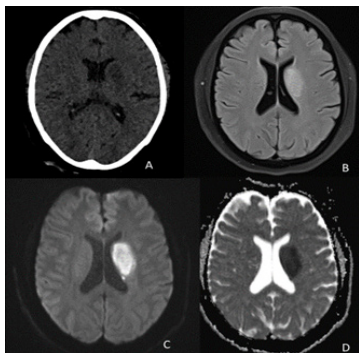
MCA territory infarct. Axial NCCT head (a) shows hypodensity in the left basal ganglia. The corresponding axial T2 (b) shows that the area is hyperintense and showing diffusion restriction on DWI (c) and ADC (d)
